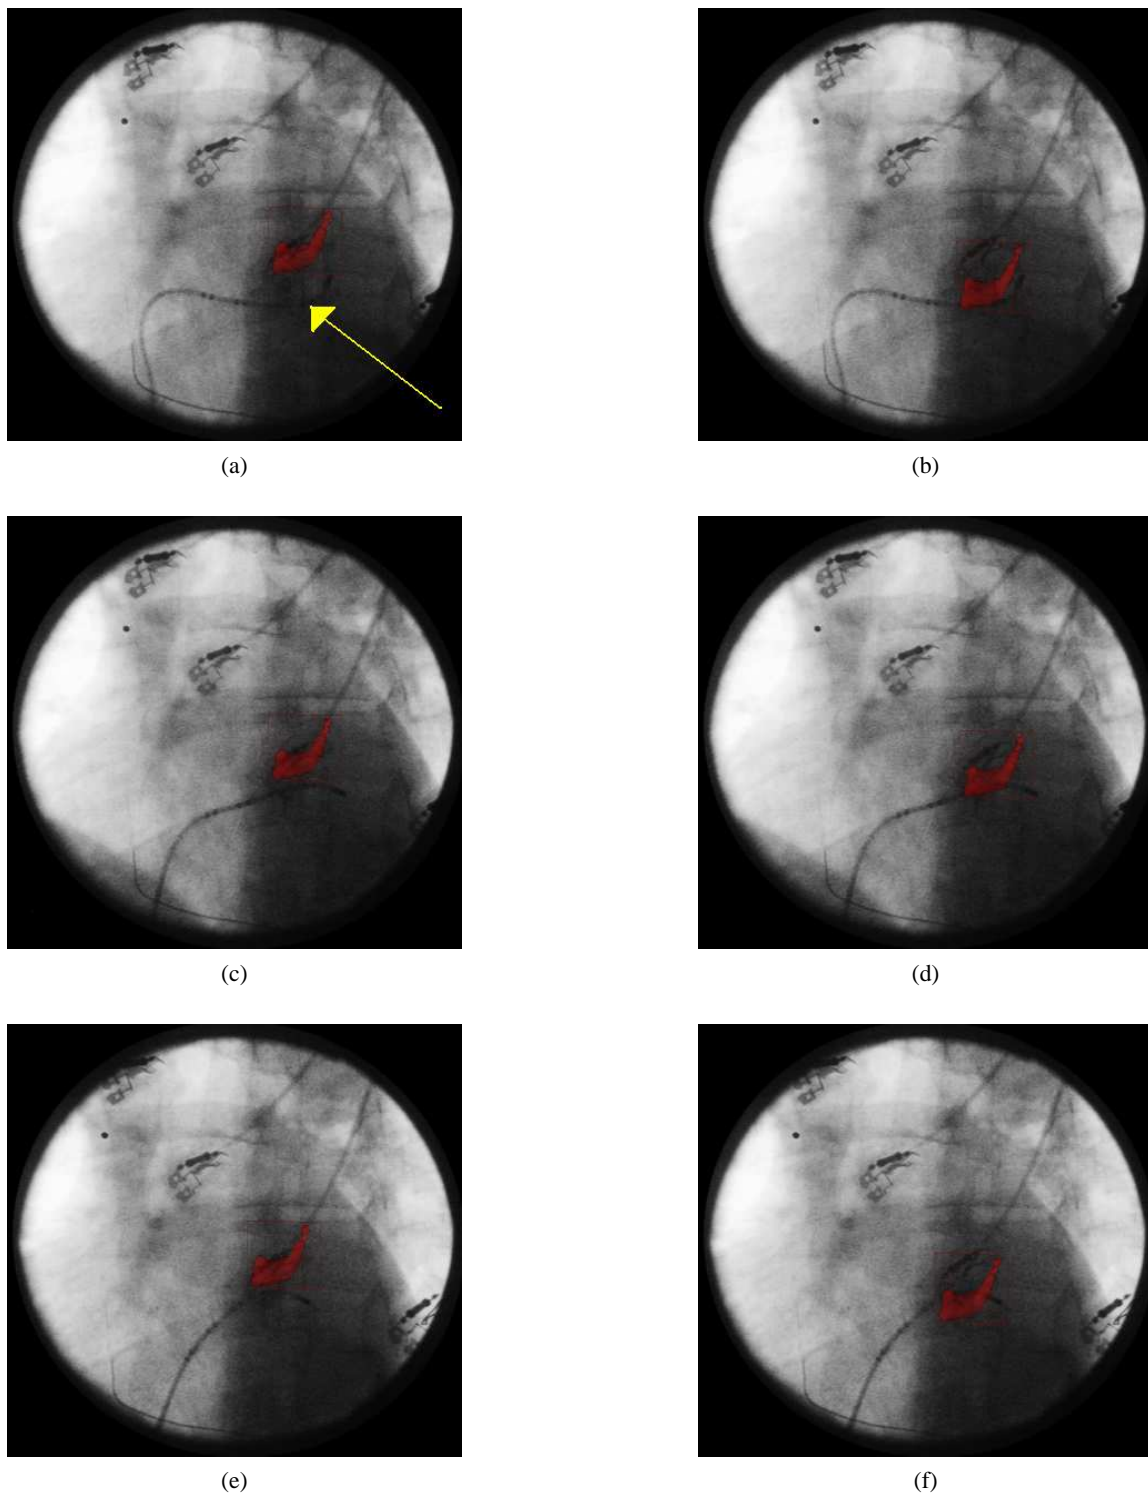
Motion correcting a roadmap using the predictive and adaptive model: (a), (c), (f): three sample frames at full inspiration from the X-ray sequence for patient A, showing the segmented coronary sinus overlay in red. The coronary sinus catheter is visible in the X-ray images and is indicated by the yellow arrow in (a); (b), (d), (f): the same three frames showing the coronary sinus overlay motion corrected using the predictive and adaptive model. The estimated misalignment between the coronary sinus catheter and the roadmap overlay was reduced from 7.7mm RMS to 2.8mm RMS after motion correction.
